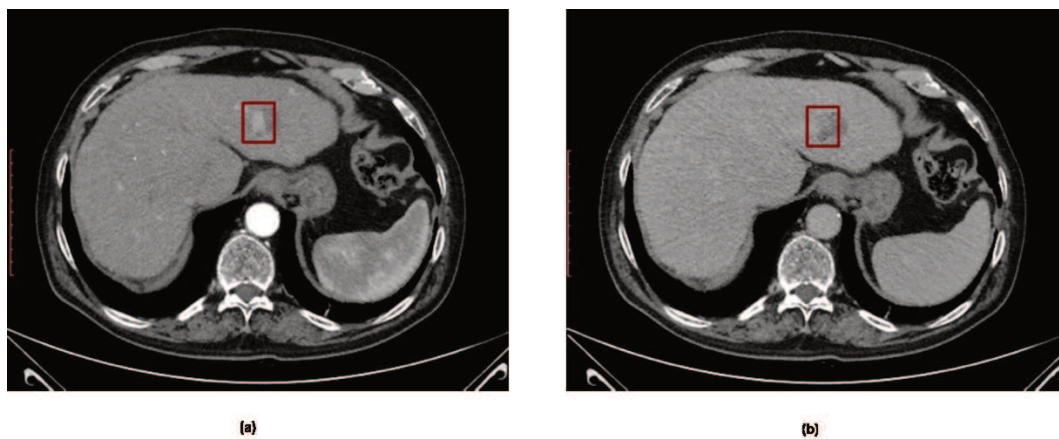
CT images acquired in the different phases: (a) Arterial phase; (b) Equilibrium phase. The square indicates the lesion in both phases
